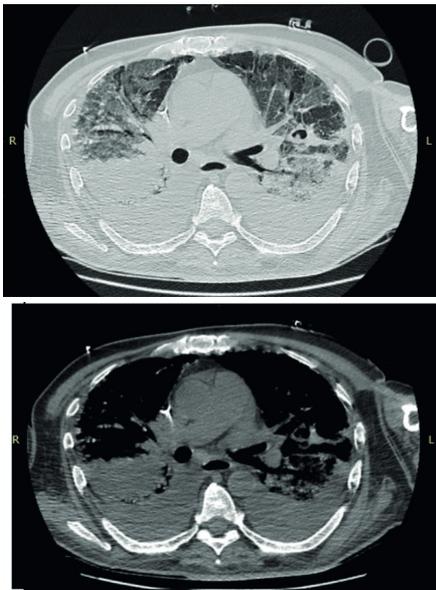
Computed tomography of the chest (05/31/21 - 9:27 pm). Bilateral diffuse ground-glass pulmonary opacities associated to an extensive area of consolidation in the posterior lung fields, characterizing an anteroposterior gradient. There is no evidence of pneumomediastinum. Well positioned tracheostome.
